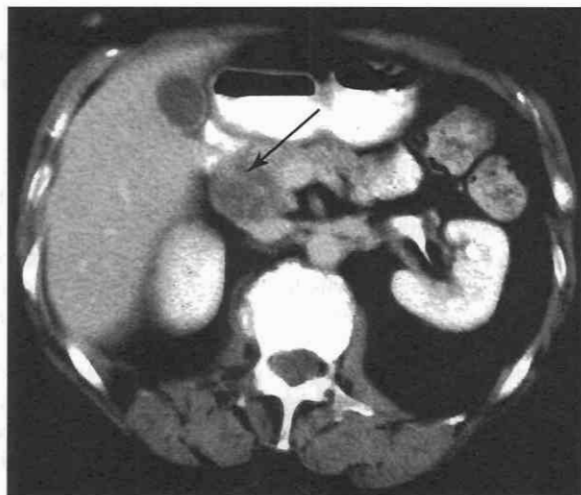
Axial CT scan shows low-density mass posterior to the head of the pancreas (arrow) from metastatic breast tumor.
